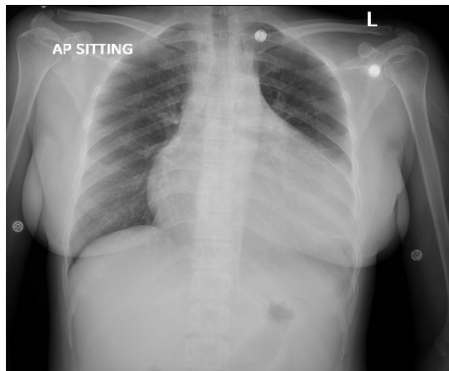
Initial chest X-ray. Note the enlarged cardiac silhouette.
